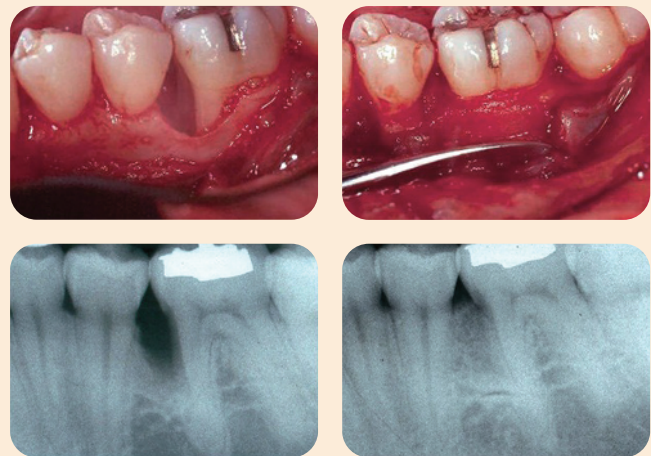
Classical intrabony defect affecting a mandibular first molar in another patient with LAP (top left). Guided tissue regeneration (GTR) was performed to regenerate the periodontal defect using bone grating and membrane (top right). Periapical radiographs depicting the vertical bony defect before (lower left) and after (lower right) GTR therapy. Significant radiographic bone fill was obtained after GTR therapy.
